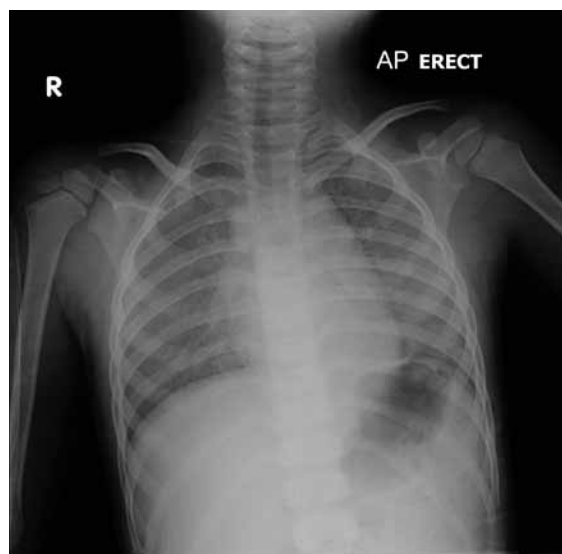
A chest X-ray showing bilateral reticulonodular haziness
